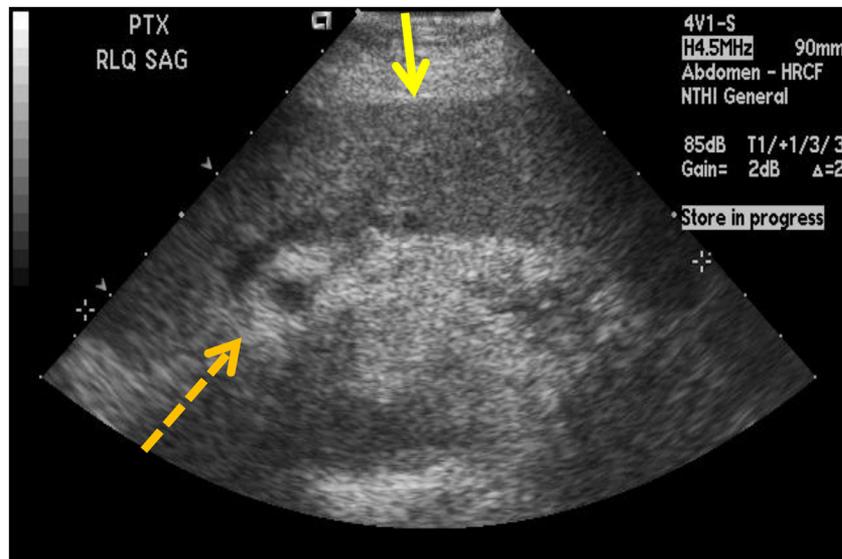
Sonographic image of a 29-year-old female reveals a normal appearing graft (solid arrow) in the right iliac fossa, which is homogenous and hypoechoic compared to the surrounding structures including visceral fat. The patient's associated donor duodenum can also be seen adjacent to the pancreas (dashed arrow) and is hyperechoic in appearance. (Color version of figure is available online.)
